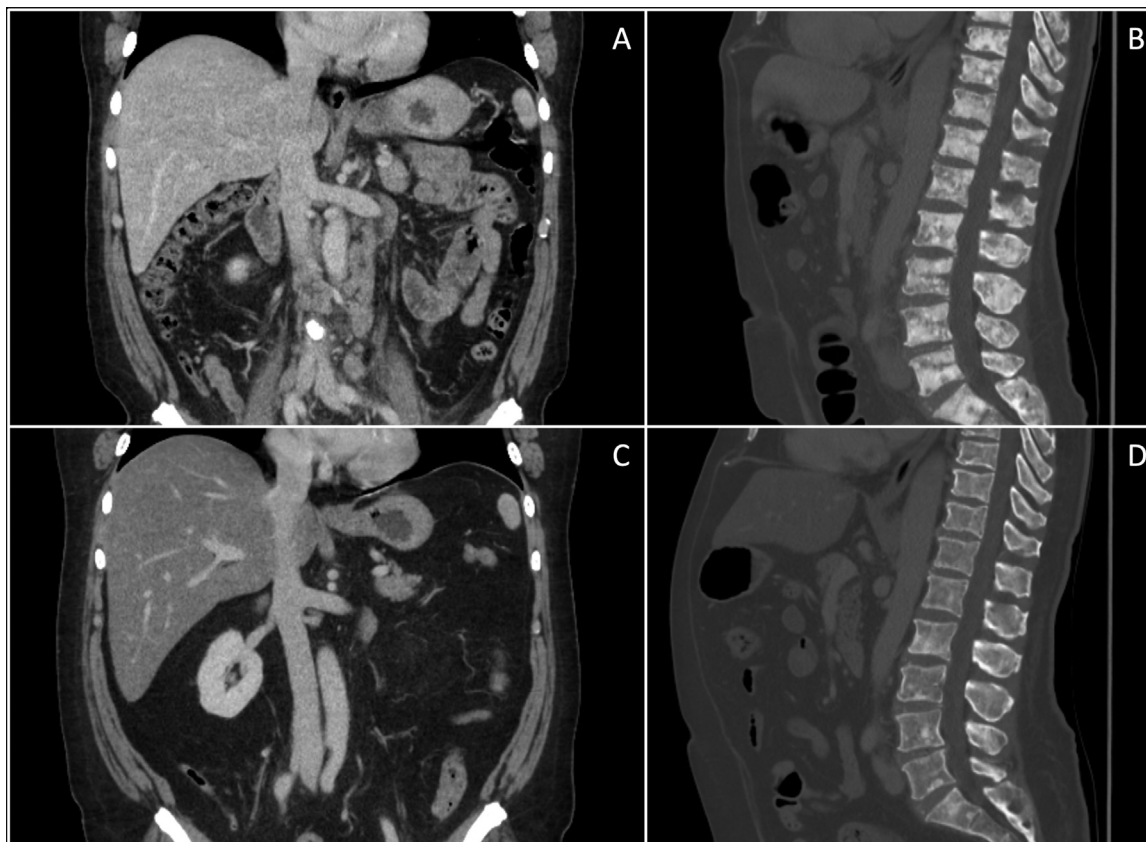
Coronal and sagittal images (A and B) from the staging CT, showing retroperitoneal paraaortic lymphadenopathy, and multifocal sclerotic bone metastases. The PSA at the time of the diagnosis measured 695 ng/mL. Six-month post-treatment images (C and D) at the same levels, show resolution of lymphadenopathy and marked improvement in bone lesions. The PSA at this time measured 1.1 ng/mL.
